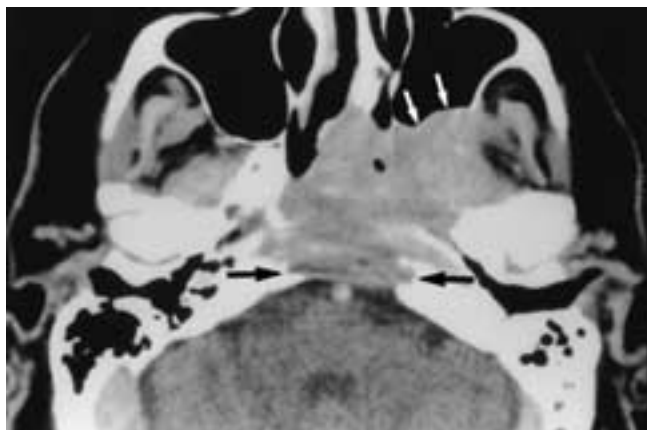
Axial contrast-enhanced CT scan shows an extensive nasopharyngeal carcinoma eroding the clivus (*black arrows*). Note the anterolateral extension into the left pterygopalatine fossa (*white arrows*).
